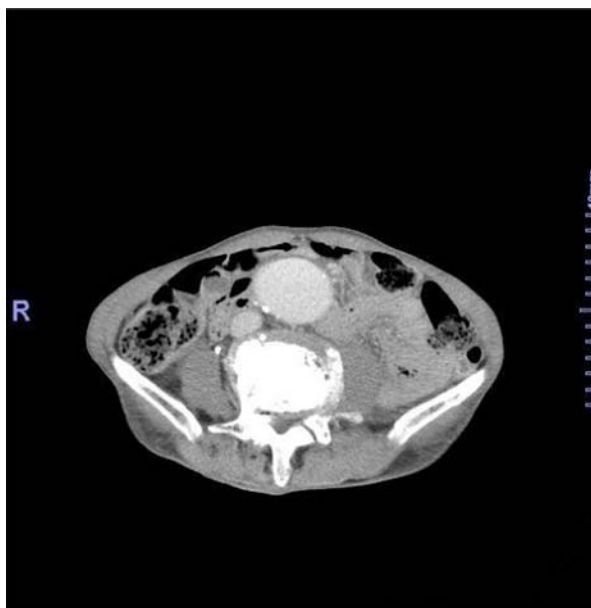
CT scan of abdominal aortic aneurysm (47.5 mm).
